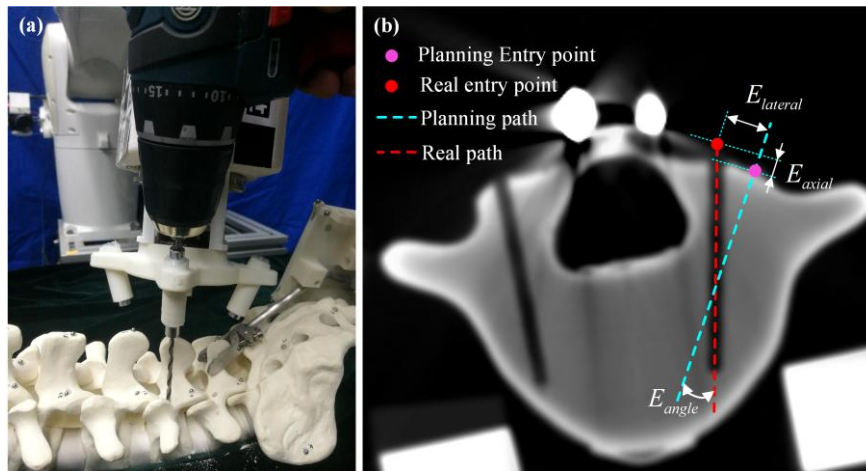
Drilling experiment. a Pedicle screw drilling. b The CT image of vertebral image after drilling and the definition of the lateral error $E_{lateral}$, axial error E_{axial} , and deviation of angle E_{angle}
